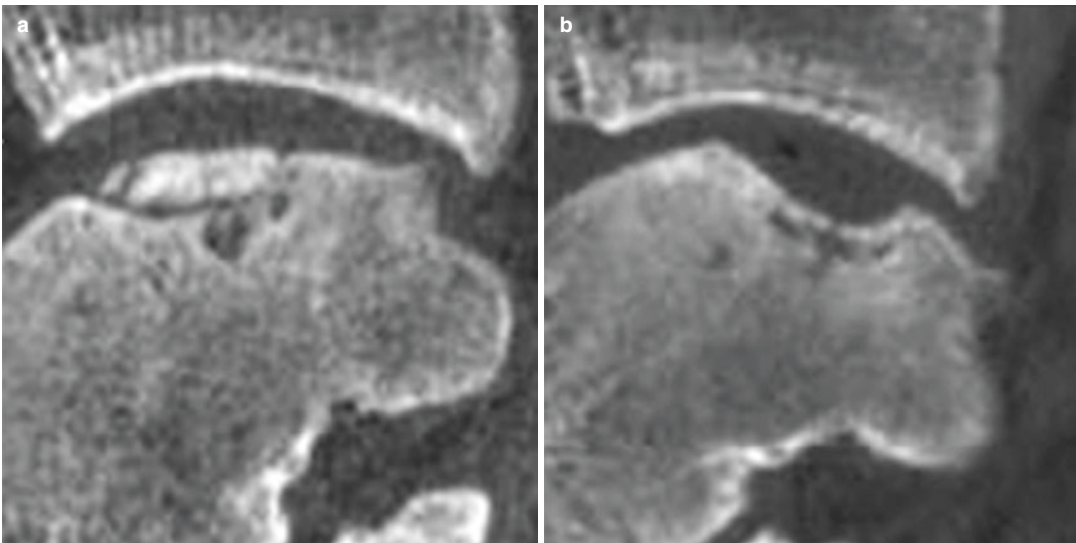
Sagittal CT scans of a talar osteochondral defect of the medial dome (right ankle). (a) Preoperative CT scan. (b) One-year postoperative CT scan after arthroscopic debridement and bone marrow stimulation (same ankle)
